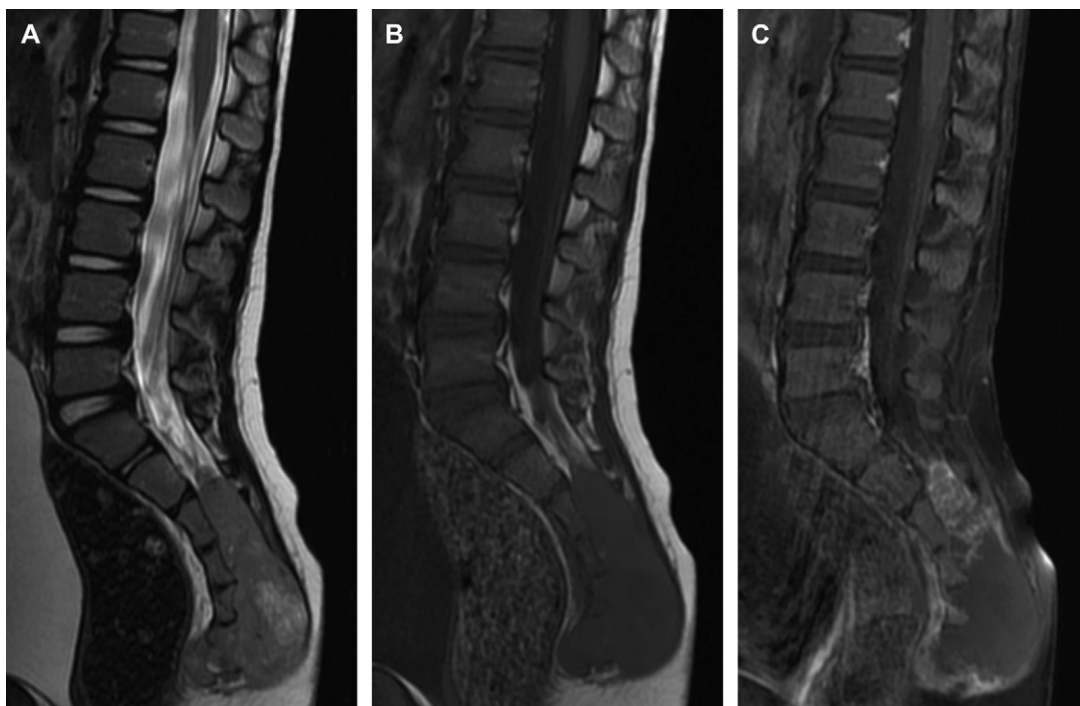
MRI of sacral atypical rhabdoid tumor in a 4-year-old girl. (A) Sagittal T2, (B) sagittal T1, and (C) sagittal T1 with gadolinium.
